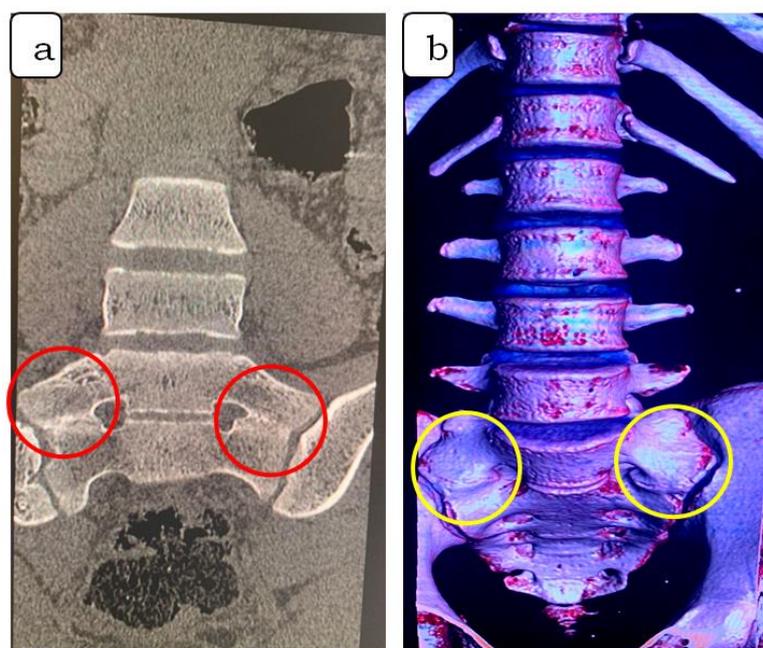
F 46 years: CT of the lumbosacral spine in coronal reconstruction and bony window in (A) and volume (B) highlighting a sacralization of L5 classified type IIIb of Castellvi (ellipses)
